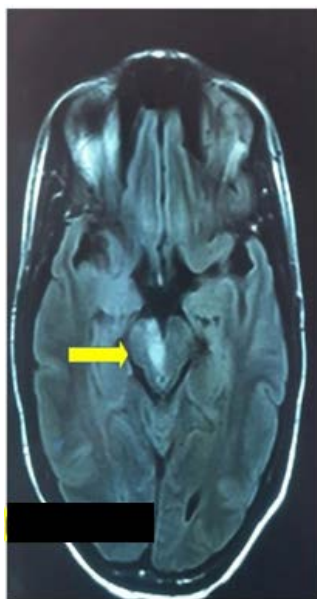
Axial T2-weighted MRI showing a pontine infarct (yellow arrow)
